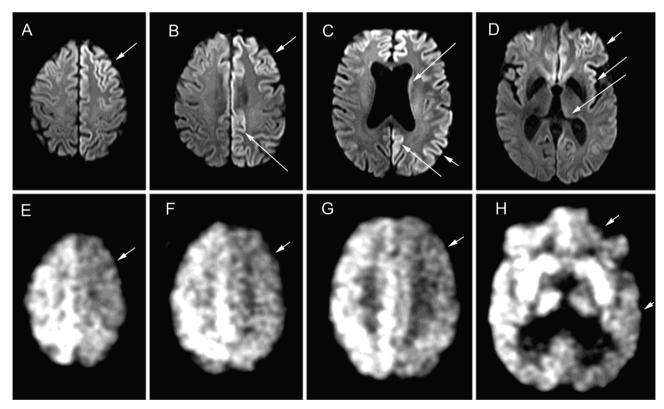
A – D: Brain MRI findings in this case. Diffusion weighted images from A, superior to D, inferior brain regions showing asymmetric restricted diffusion (bright signal, arrows) in the cortical ribbon more prominently in the left hemisphere in prefrontal, posterior parietal and retrosplenial cortices, as well as the insula and cingulate gyrus, with faint signal abnormality also in the body of the caudate nucleus (in C) and pulvinar of thalamus (in D). E-F: 18-FDG PET findings in this case, showing hypometabolism in areas of restricted diffusion.
